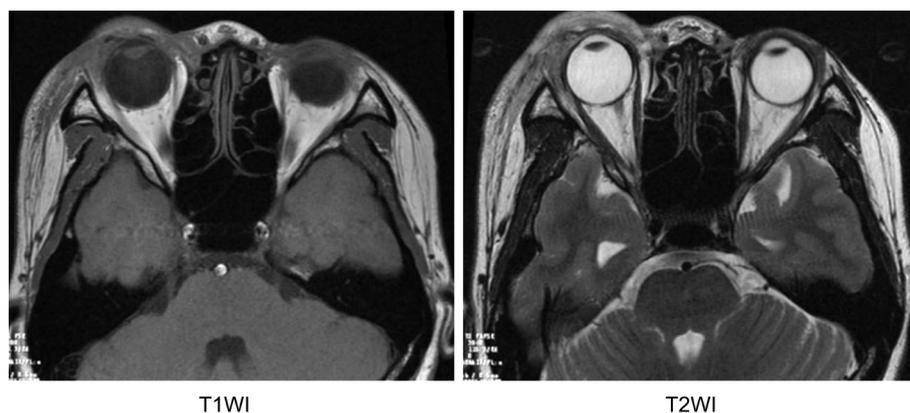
MRI scanning result for one case of IOID patient T1WI and T2WI revealed the thickening eyelid and soft tissue on cheekbones. Lesions involved rectus muscle of the right orbit and the extraconal orbital compartment. The right eyeball showed deformation due to the high pressure, and the right lacrimal gland enlarged.
